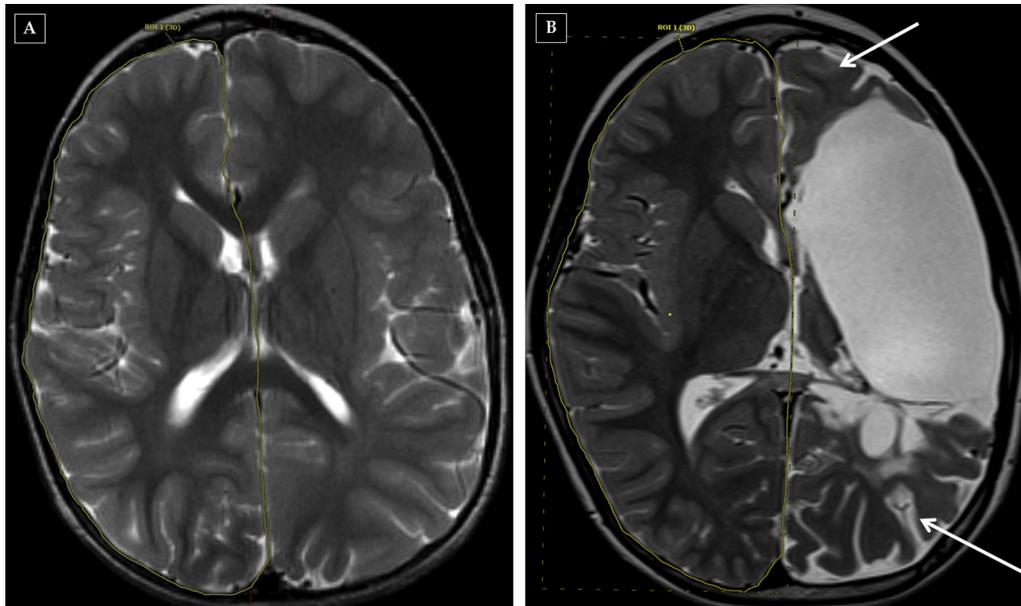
Axial T2-weighted images of a patient with left hemimegalencephaly who had a modified lateral hemispherotomy at age two years and four months. Three-dimensional manual contouring is represented by the yellow outline of the right hemisphere on (A) preoperative examination two weeks before surgery and (B) postoperative examination four years and 10 months after surgery. Note the atrophy in the unremoved portions of left hemisphere (arrows) despite preserved vascular supply, and the nonatrophic right hemisphere. The color version of this figure is available in the online edition.
